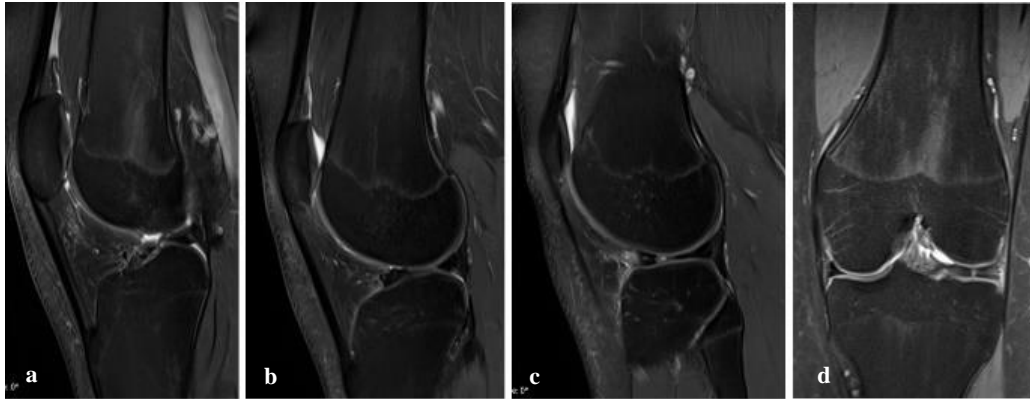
(a-d): Left knee magnetic resonance imaging.
